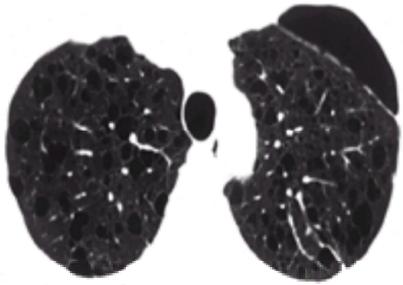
Lymphangioleiomyomatosis. CT in a 41-year-old woman with LAM demonstrates multiple, thin-walled cystic radiolucencies in upper lobes bilaterally with large zones of intervening normal lung parenchyma, consistent with LAM.
